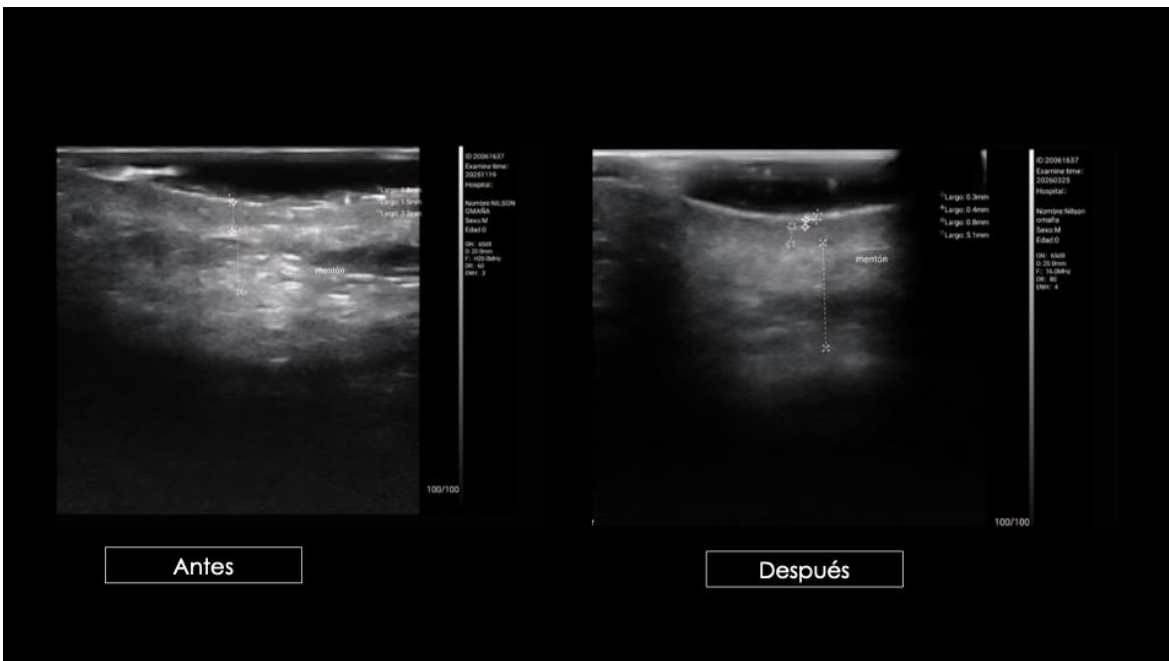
Ultrasound analysis before and after six sessions of adipostructuring at three months of follow-up. Oral and Maxillofacial Surgery Service, Pérez de León II Hospital, Caracas, Venezuela.
